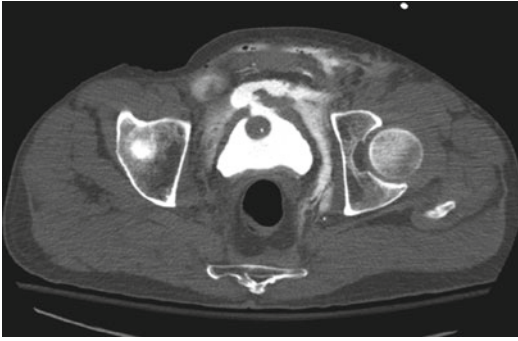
CT cystogram of an extraperitoneal bladder rupture exhibiting the “molar tooth” sign. Lateral extravasation of contrast forms the “roots” of tooth while anterior extravasation forms the “crown”
